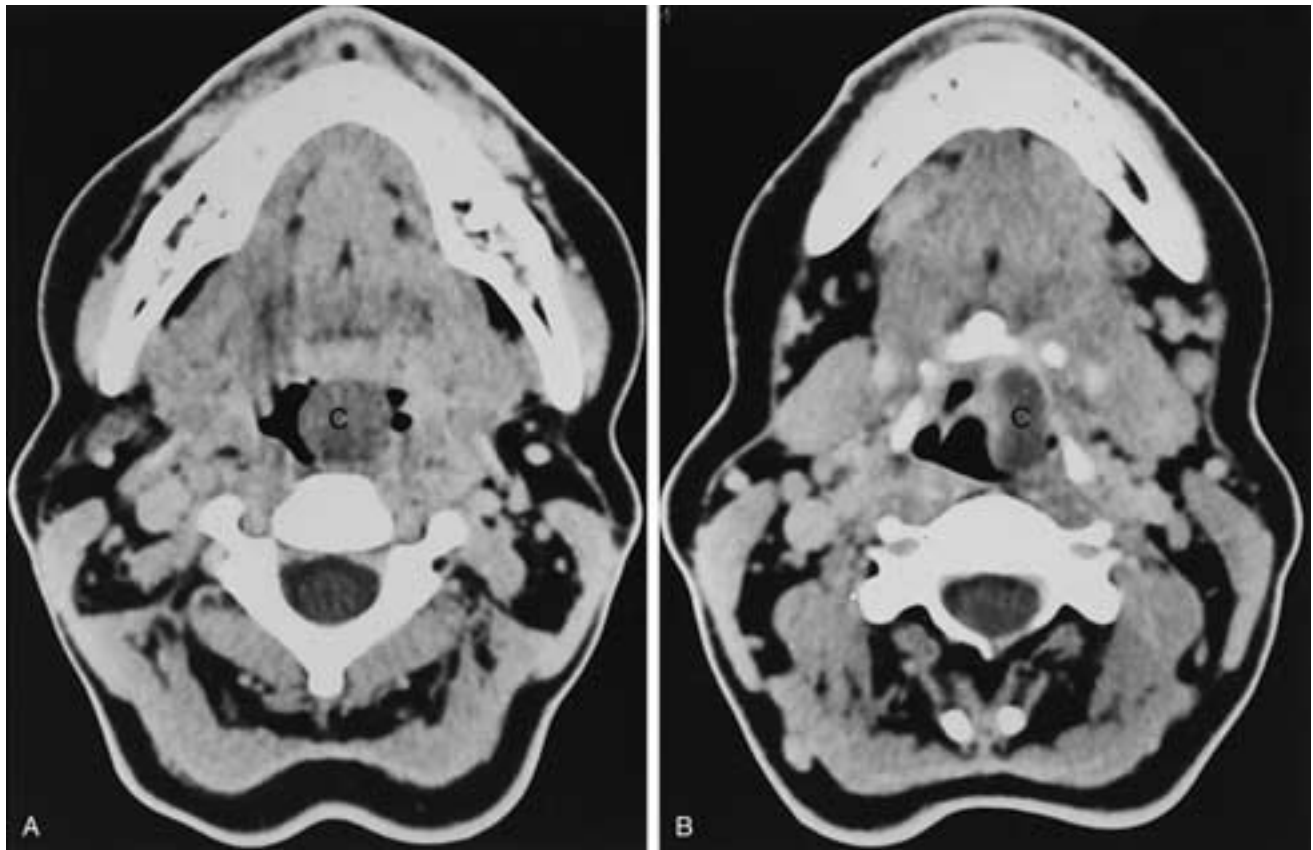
A, Vallecular cyst on CT. Midline cyst (C) seen at the level of the base of the tongue. B, Slightly lower level shows the origin of the cyst in the left valleculae deforming the epiglottis. C, Cyst.
